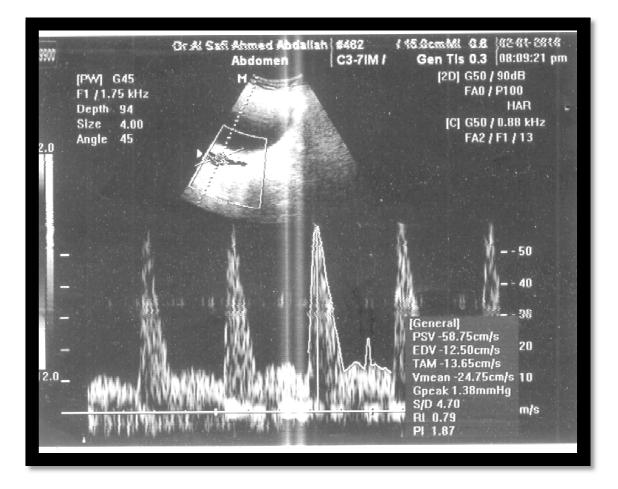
Color Doppler scan for a 24 years old lady (RPL) .The Sagittal abdominal scan shows complete abortion.
